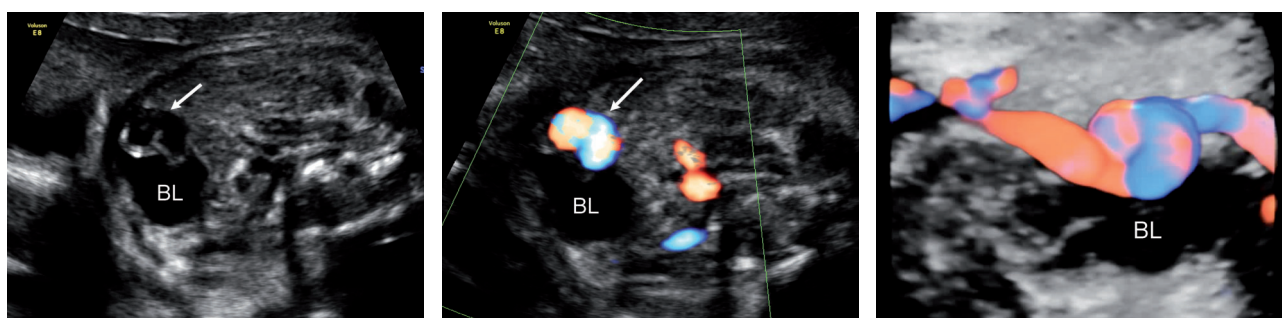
Tortuous intra-abdominal segment of isolated single umbilical artery. A) Axial section of left SUA on two-dimensional ultrasound. U-shape of SUA is found along left side of bladder (arrow). BL: bladder. B) Two-dimensional high-definition flow imaging of left SUA. Opposite flow direction is found in the U-shape of SUA (arrow). BL: bladder. C) Three-dimensional high-definition flow imaging of left SUA. The dilated and tortuous SUA (omega sign) is noted. BL: bladder.
